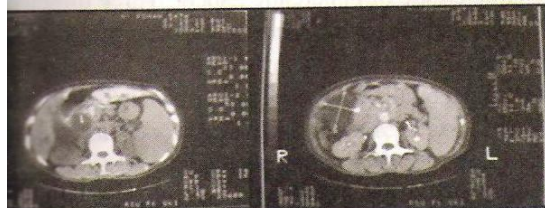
CT scan of abdomen and pelvis reveals enlargement of pancreatic duct, intrahepatic bile duct and ascites
